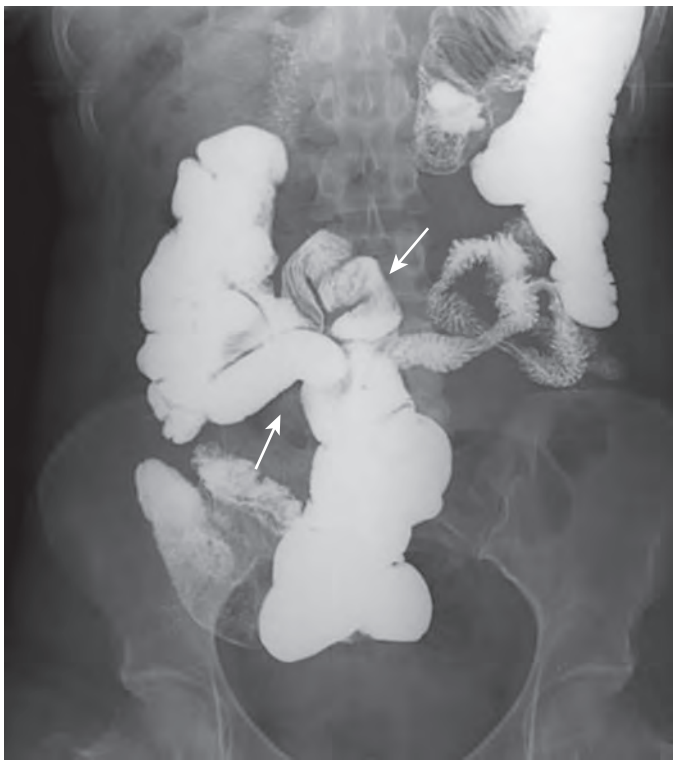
Internal hernia following RYGB. An overhead radiograph during UGI with small bowel follow-through on an RYGB patient shows an atypical bowel configuration, with clustered, displaced small bowel loops in the right midabdomen. A small bowel limb can be seen entering and exiting the clustered segment (arrows).
